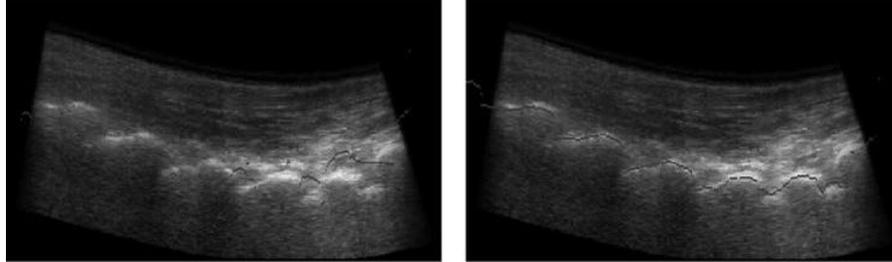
Registration of an in vivo dataset of a human lumbar spine. Shown are sagittal slices through the three-dimensional ultrasound dataset in the area of the laminar arc. The gray lines indicate the position of the bone surface extracted from the CT-dataset. (left: before registration, right: after registration)
